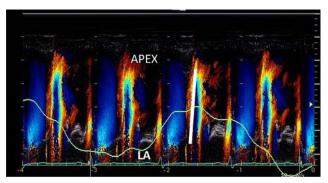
Characteristic color M-Mode echocardiographic findings in a patient with CP showing the rapid (100 cm/sec) flow propagation slope (line at the junction of the *red-yellow* aliasing velocity) from the left atrium (LA) to the apex of the left ventricle.
